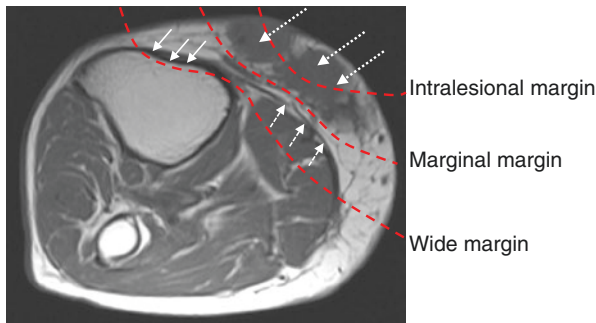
Axial T1-weighted MRI of subcutaneous soft tissue sarcoma in lower leg (dotted arrows). Intralesional margin passes through subcutaneous tumour. Marginal margin passes through inflammatory pseudocapsule. Wide margin passes deep to periosteum of tibia, under deep fascia and includes layer of gastrocnemius. Periosteum (solid white arrows). Deep fascia (dashed white arrows). Margins (dashed red line)
